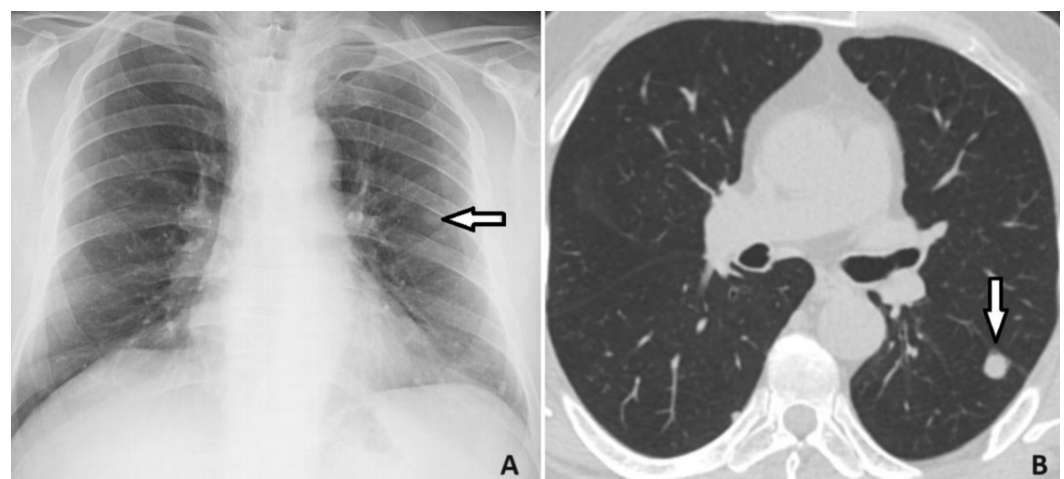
Radiological findings of the patient. On posteroanterior chest radiography, a homogeneous radio-opaque lesion (white arrow) with smooth margins in the left lung (A). On chest computed tomography, a 1 cm diameter, smooth-edged, homogeneous, soft tissue nodule (white arrow) in the left lower lobe of the lung (B).
